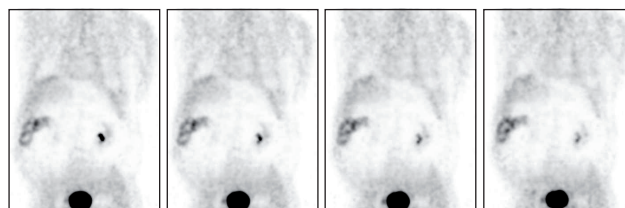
Images of <sup>18</sup>F-FDG-PET in another patient demonstrate clear evidence for inflammatory bowel disease in the hepatic flexure region, which was the cause of this patient's fever. Final diagnosis was reached by intestinal biopsy.
